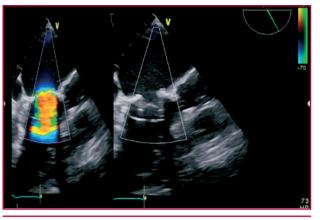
SAPIEN XT valve in mitral position; evaluation with transesophageal echocardiography with Doppler (left) and without Doppler (right).
